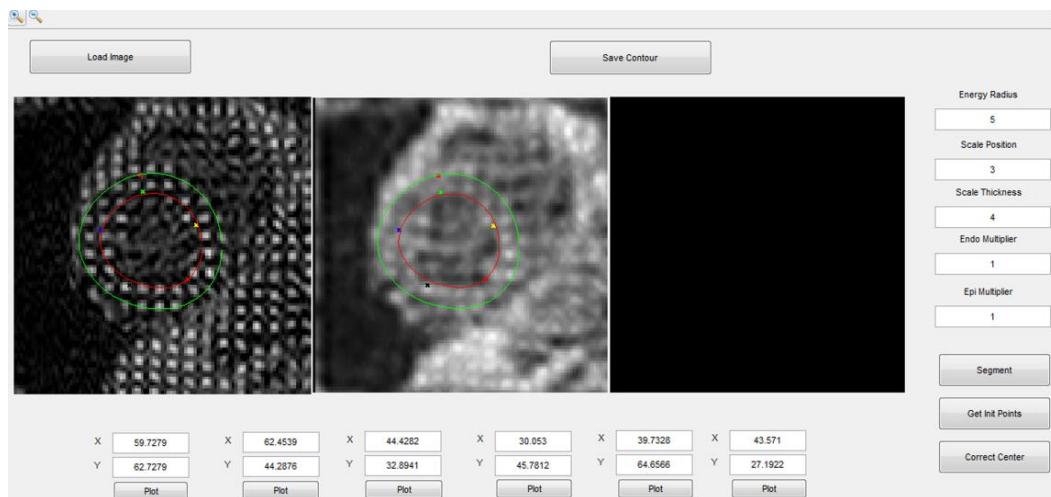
Interface developed for assess the automatic segmentation of the LV in t-MRI.
